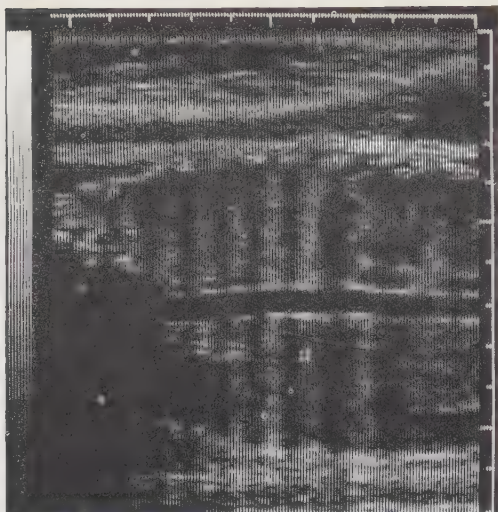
Ultrasonic longitudinal section of descending aorta in a human fetus (37th gestational age). The white marker indicates the persistent, well defined angle representing the passage of the vessel through the diaphragm.
